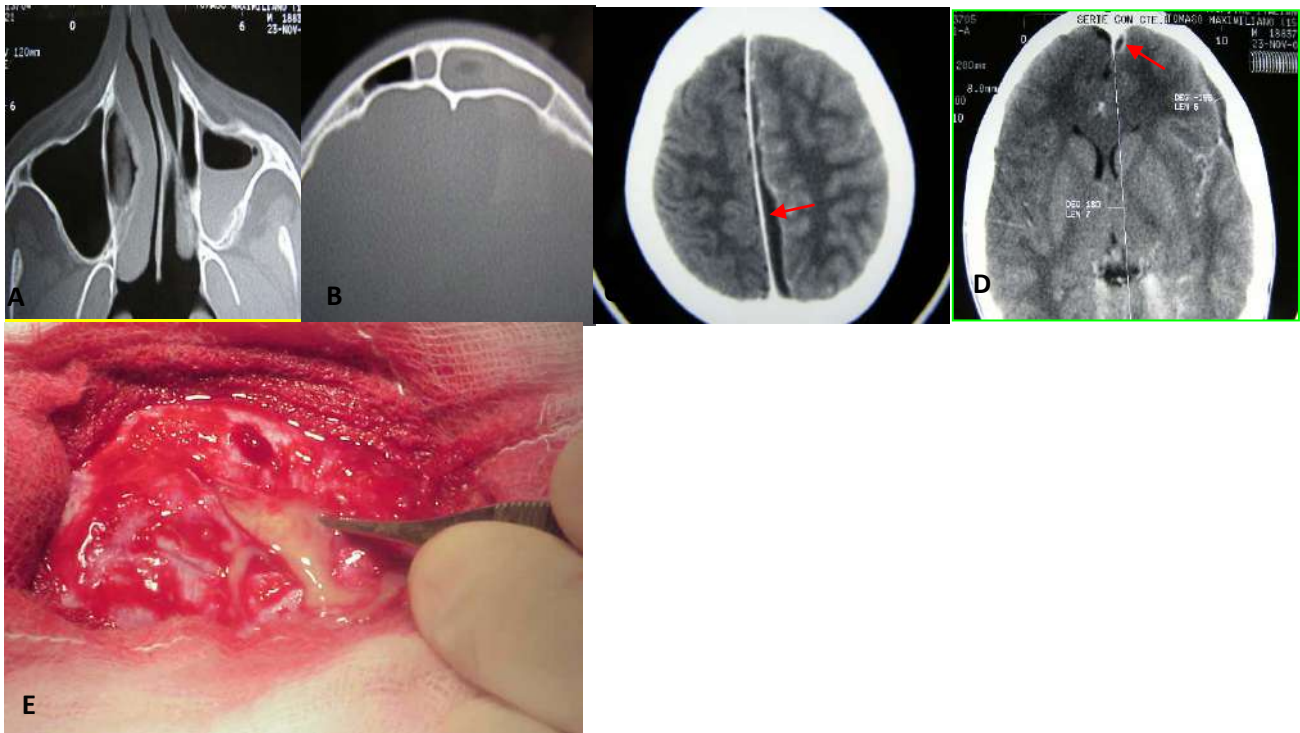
A-B: Facial CT with contrast, axial sections showing left maxillary-ethmoidal-frontal sinusitis, C-D: MRI showing frontotemporal and occipital subdural abscesses (red arrows), E: Craniectomy and drainage of intracranial abscesses
